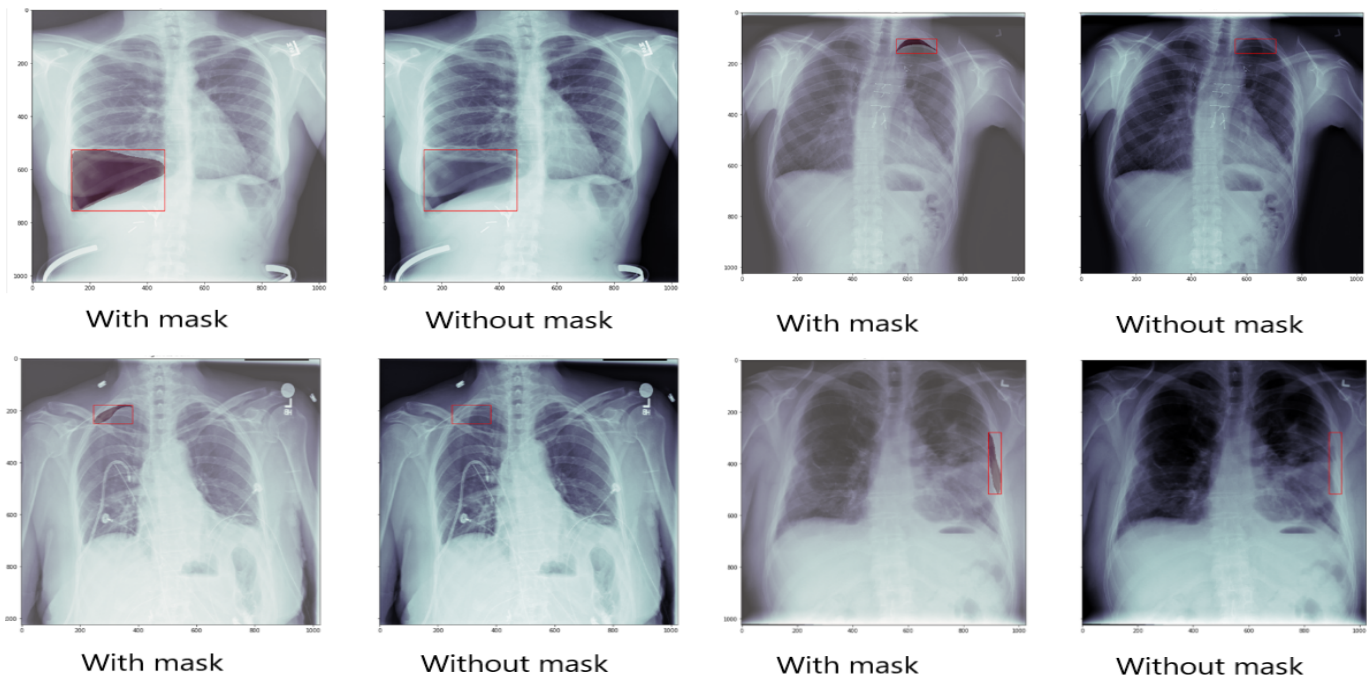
Samples of chest X-ray image containing pneumothorax
